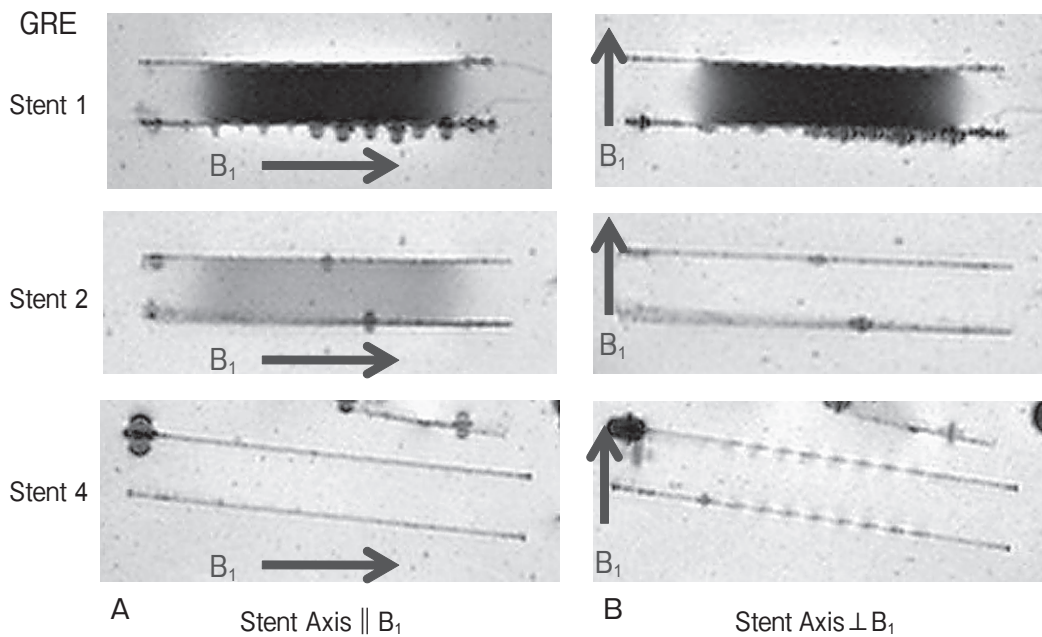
Sagittal GRE MR images of Stent 1 (mesh pattern), Stent 2 (solenoid pattern), and Stent 4 (Moebius pattern). A, The stent axes are parallel to B₁; B, The stent axes are perpendicular to B₁.
